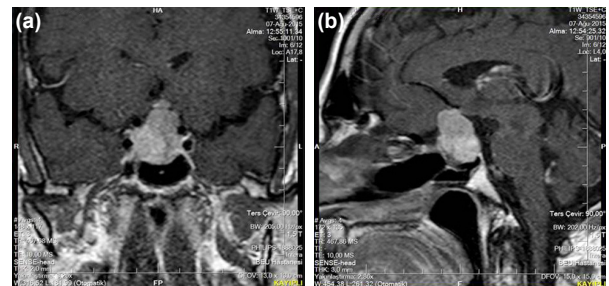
Lesion progression is seen at the third-month control biopsy. The suprasellar extension of the tumor was compressing the optic chiasm. The tumor invaded the cavernous sinus on the right side and filled the infrasellar space. (a) Coronal T1 C+ magnetic resonance imaging (MRI). (b) Sagittal T1 C+ MRI.
